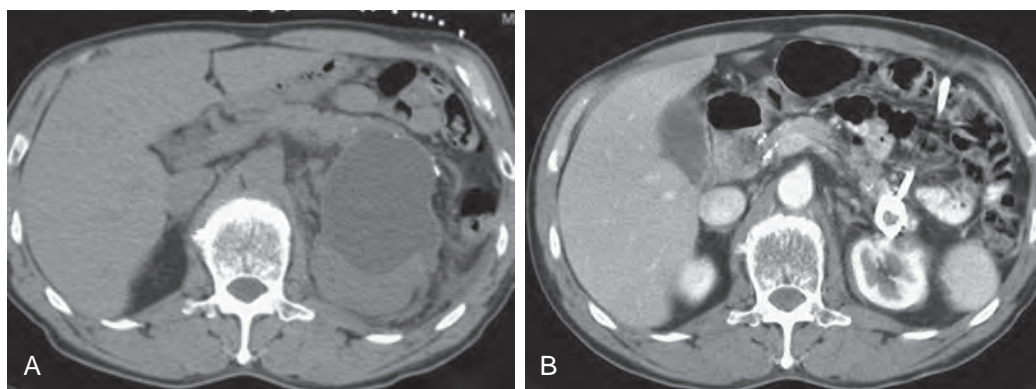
Percutaneous catheter drainage of infected pseudocyst (pancreatic abscess). A. Axial nonenhanced CT image shows well-defined fluid collection adjacent to the tail of the pancreas with peripheral calcifications consistent with pancreatic pseudocyst. The collection was needle sampled through a left anterior approach; the fluid was analyzed and found to be infected. B. Axial contrast-enhanced CT image obtained 3 weeks later shows complete resolution of the infected pseudocyst.
